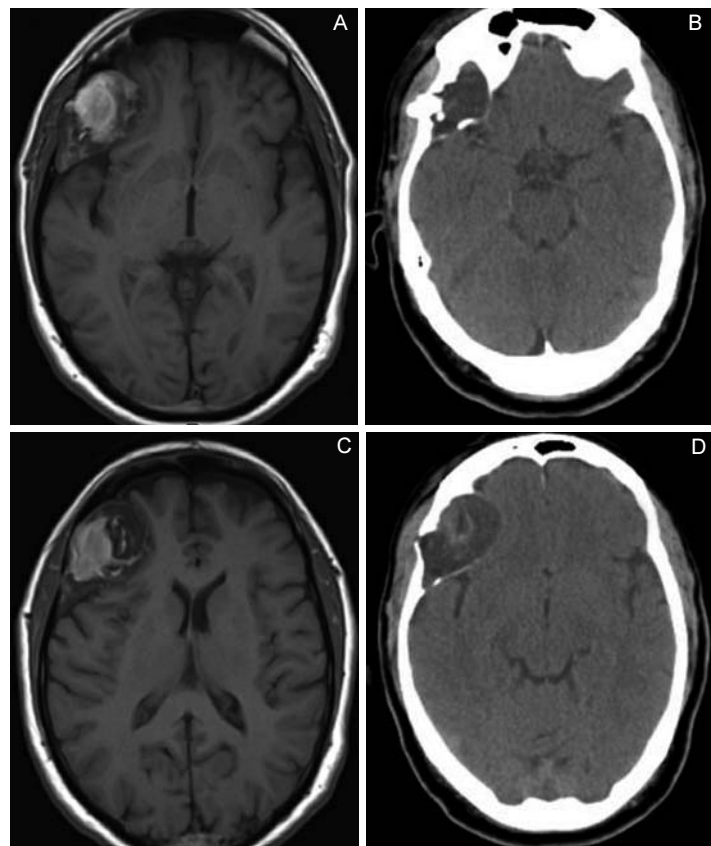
Male, 69 years of age, with visual disorders and drug resistant headache. Dermoid cyst of the sphenoid wing, in T1 weighted RMI sequence, without contrast medium, in axial section (A, C). CT scan of the same lesion in axial section (B,D).
